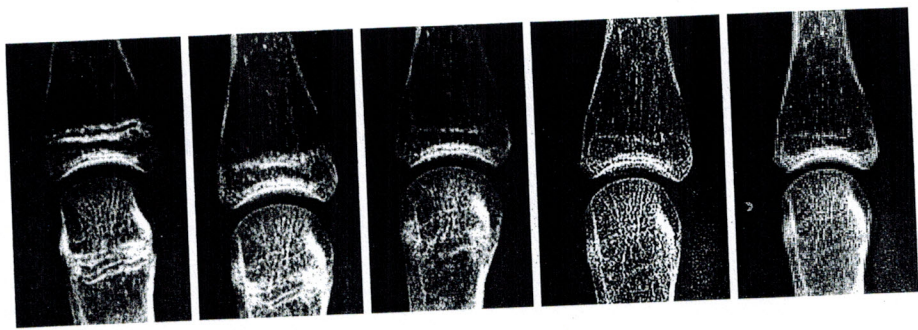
X-ray images of the development of the epiphyseal closure (base of the left digitus IV) before and during estradiol replacement therapy in the propositus.
